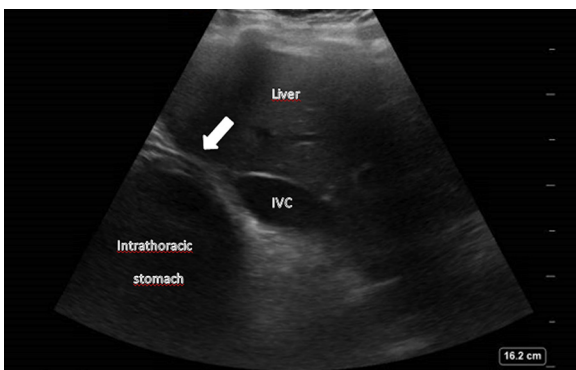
Ultrasonographic image demonstrating compression of the inferior vena cava by the intrathoracic part of the stomach. Arrow indicates the point of inferior vena cava compression by the intrathoracic part of stomach. IVC, inferior vena cava.
